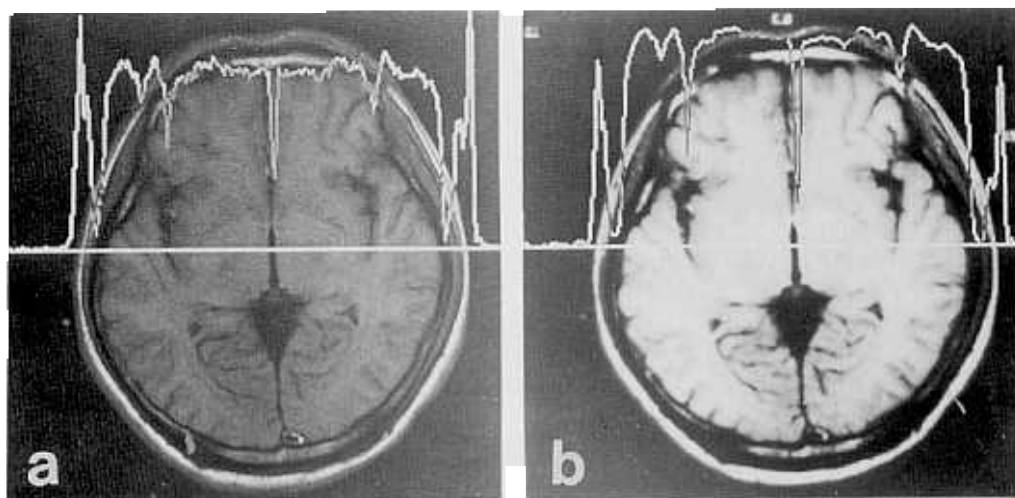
Above figure is for comparing the qualities of a digitally transferred image (a) and a scanned image (b) of the same MR image. Graphs in the middle of each image are intensity plots along the same horizontal lines.
